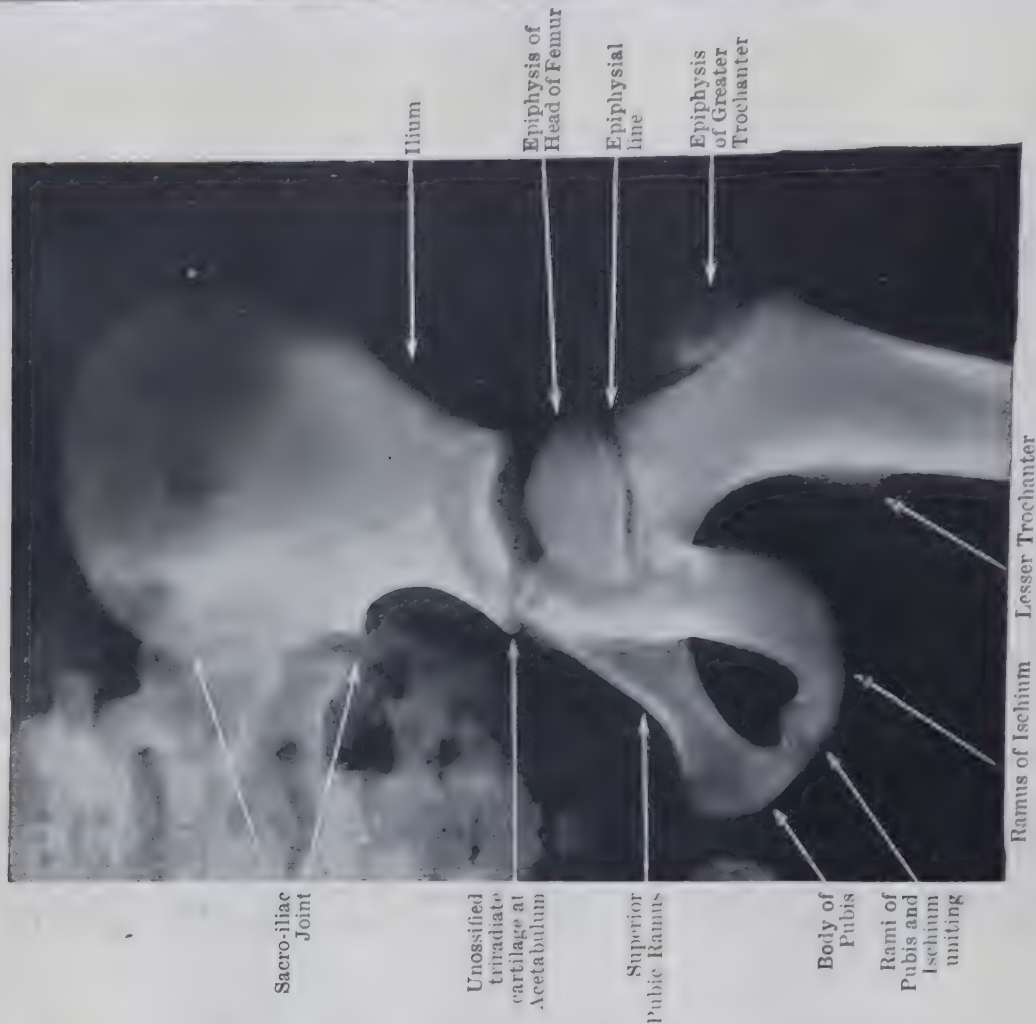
RADIOGRAPH OF HIP OF BOY AGED 7. (Dr. J. Duncan White.)
